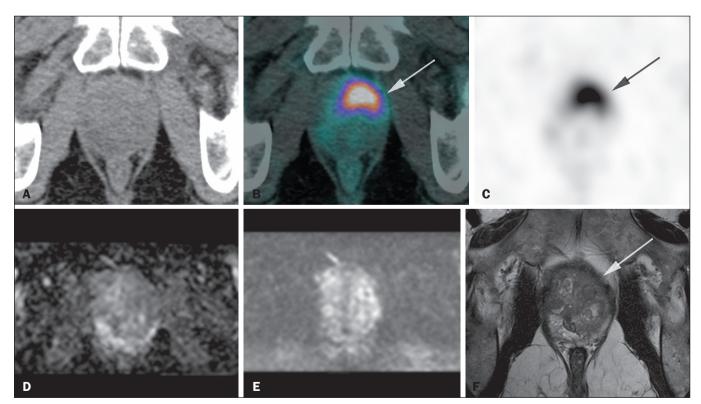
A 67-year-old patient with a serum PSA of 23.1 ng/mL. The image shows intense radiopharmaceutical uptake in an area centered on the anterior midline and to the left in the apical portion of the prostate, affecting the transition zone, with an SUVmax of 14.9 (A: CT; B: ⁶⁸Ga-PSMA PET + CT fusion; C: ⁶⁸Ga-PSMA PET/CT), which corresponds to the area at the apex to the left of the transition zone, with a discrete hypointense signal on T2-weighted sequences, without significant restricted diffusion on diffusion-weighted imaging and without alteration in the perfusion study on mpMRI (D: apparent diffusion coefficient map; E: diffusion-weighted image).
